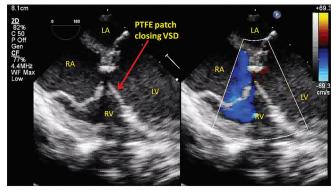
Trans-esophageal echocardiography mid-esophageal for chamber view, PTFE patch after closure of ventricular septal defect (VSD; red arrow) and severe LV dysfunction. PTFE: Polytetrafluoroethylene, LA: Left atrium; LV: Left ventricle; RA: Right atrium; RV: Right ventricle
